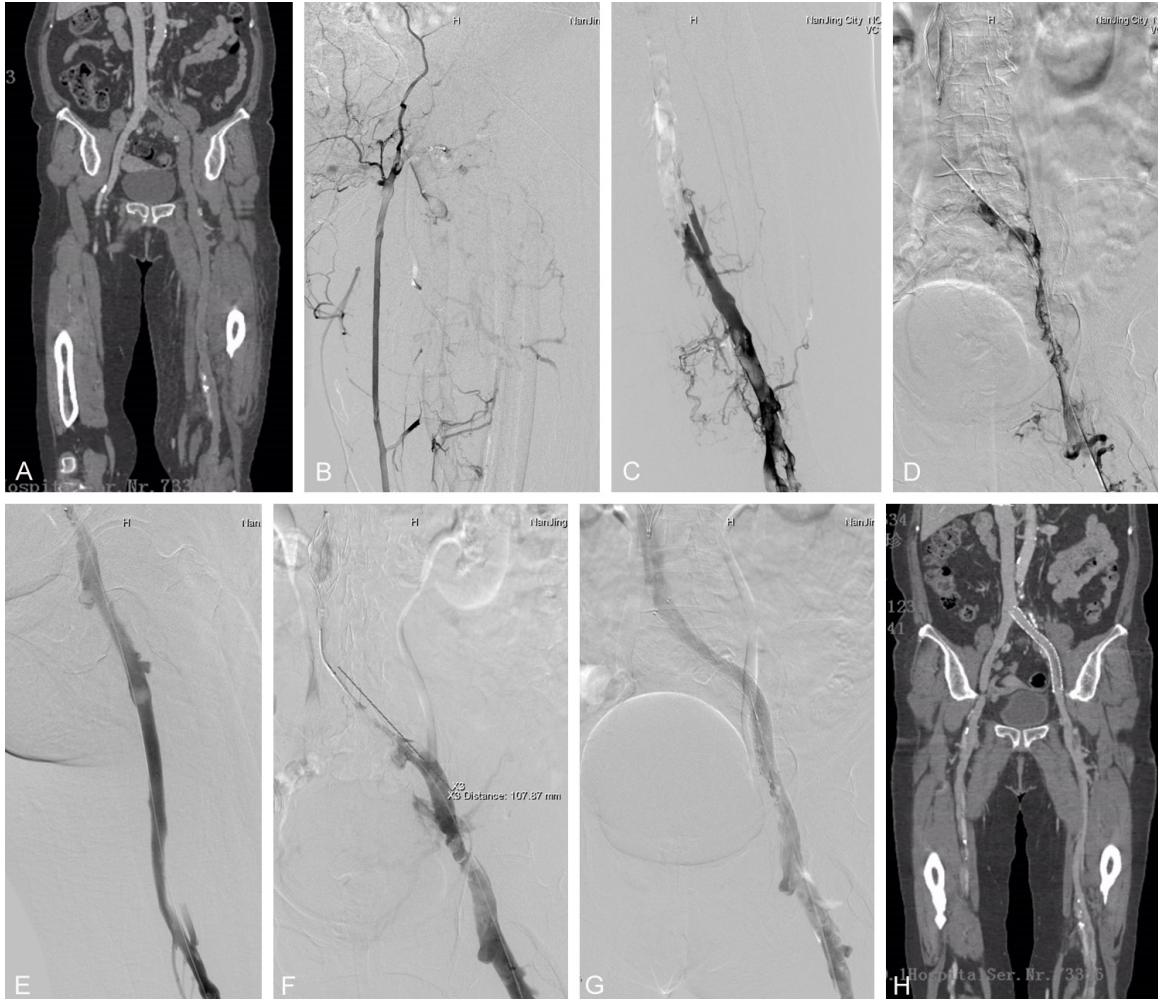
A 70-year-old female whose left lower extremity swelled for 3 days due to no obvious reasons. A, B. Lower-extremity vein CTA and left foot dorsal vein angiography indicated iliofemoral venous thrombosis. C, D. Inferior vena cava filter was implanted through the right lateral femoral vein. Angiography showed large amount of thrombus in the left iliofemoral vein. E, F. AngioJet thrombectomy device was implanted through the exchange guide wire and PMT was performed. Angiography indicated iliac vein compression syndrome. G. Stent implantation in the left iliac vein completely restored vein patency. H. CTA review at 6 months after surgery showed patent blood flow in the iliofemoral vein, with satisfactory stent position.
